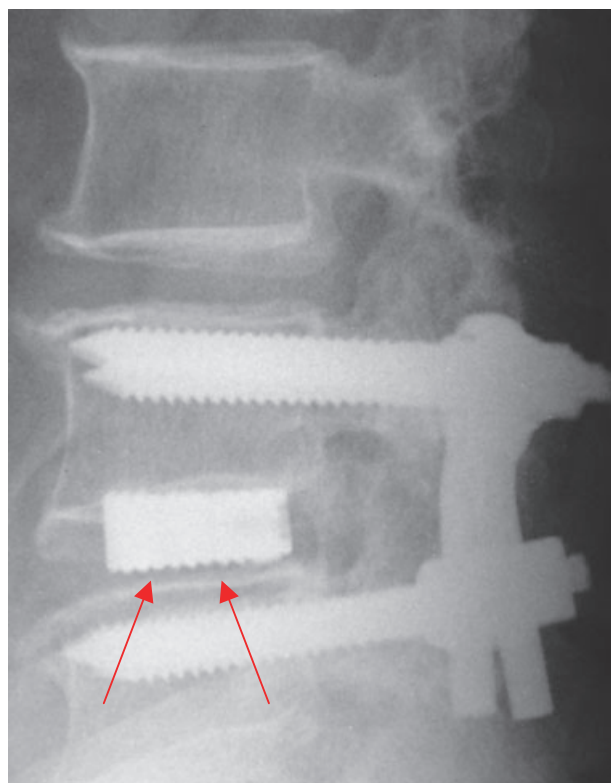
Follow-up radiograph. The arrows indicate absence of anterior fusion.
